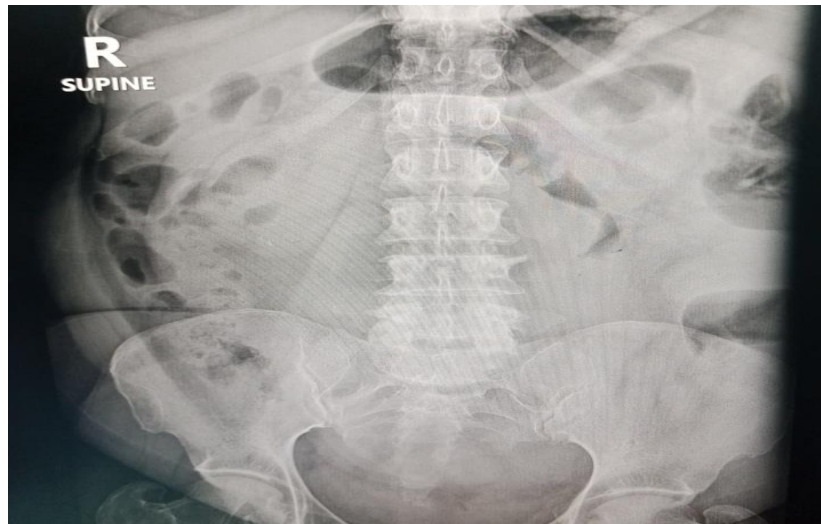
Control radiograph showing a soft tissue density lesion arising from the pelvis, more to the left side up to the level of L2 vertebral body-Leiomyoma. Note degenerative changes in the lumbar spine.
